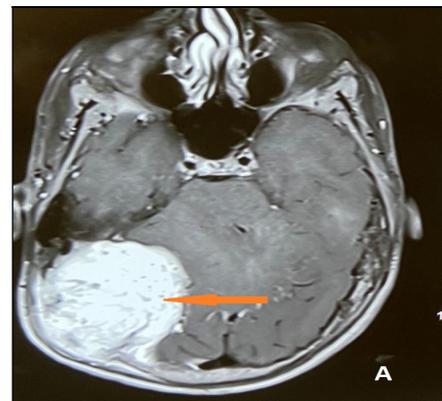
MRI (axial) T2 flair weighted image shows a hyperintense well defined expansile lesion (red arrow) measuring 5.2×5.6×5.3 cm in the right occipital region
